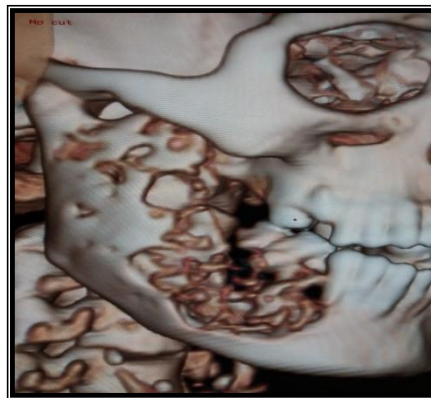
Three-dimensional CT showing sagittal view
